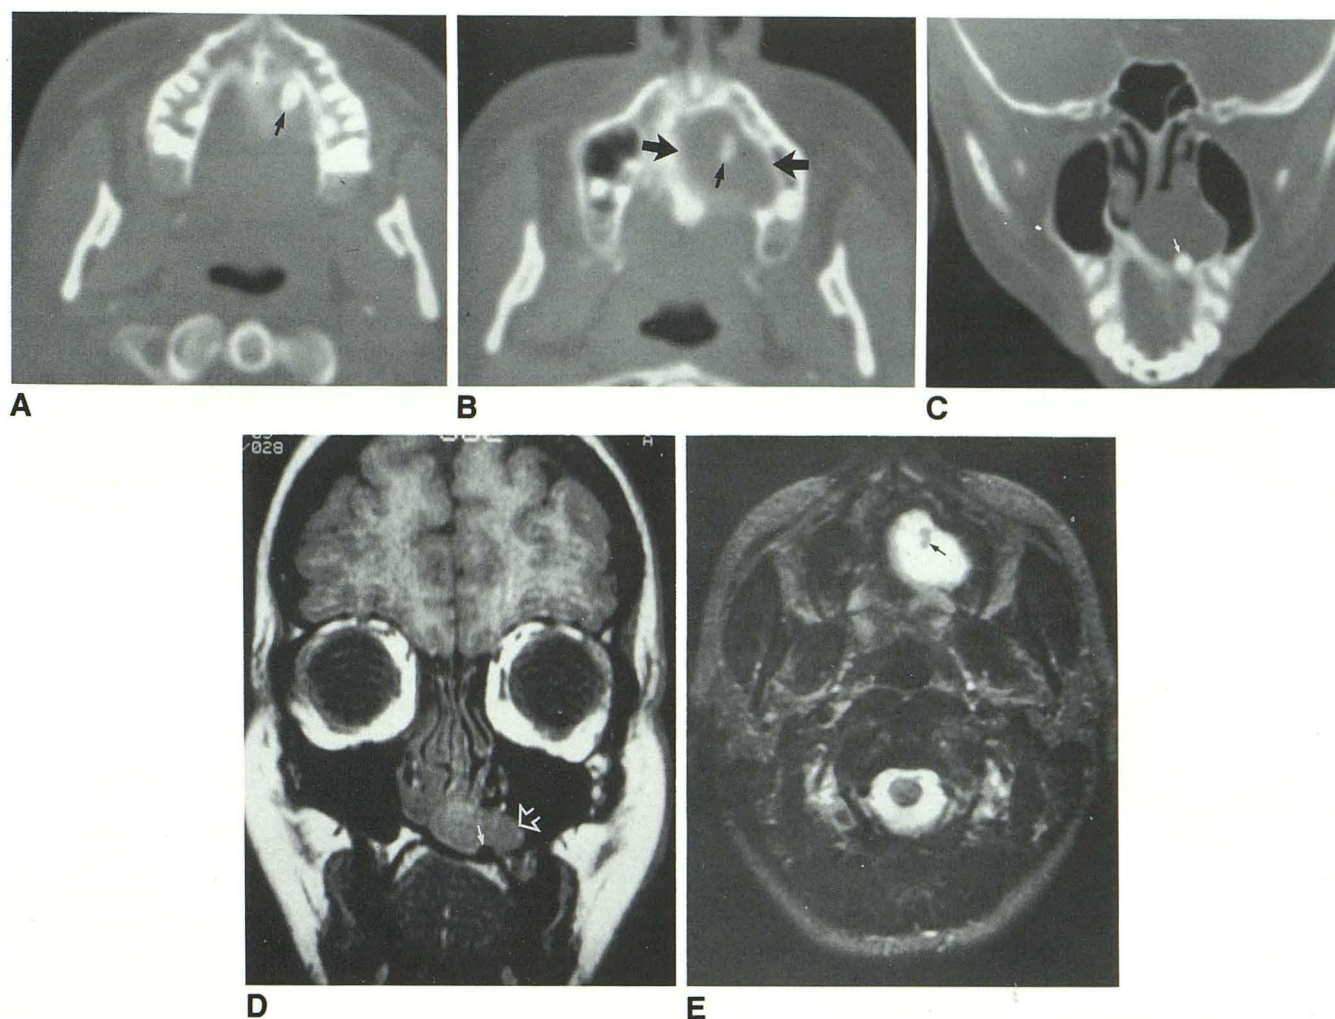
A–C, CT scans: Axial wide window setting CT scans show (A) a conical, supernumerary tooth in the left hard palate (arrow) positioned just behind the maxillary alveolus more cranial scan (B) shows the cystic erosion in the hard palate (big arrows) and the top of the tooth (small arrow). Coronal scan (C) shows the expansile, cystic palatal, and nasal floor mass, and the supernumerary tooth (arrow). Also shown are all of the anterior maxillary teeth in normal position.
